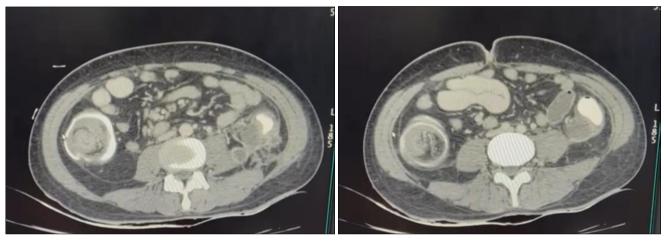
CT scan of abdomen
